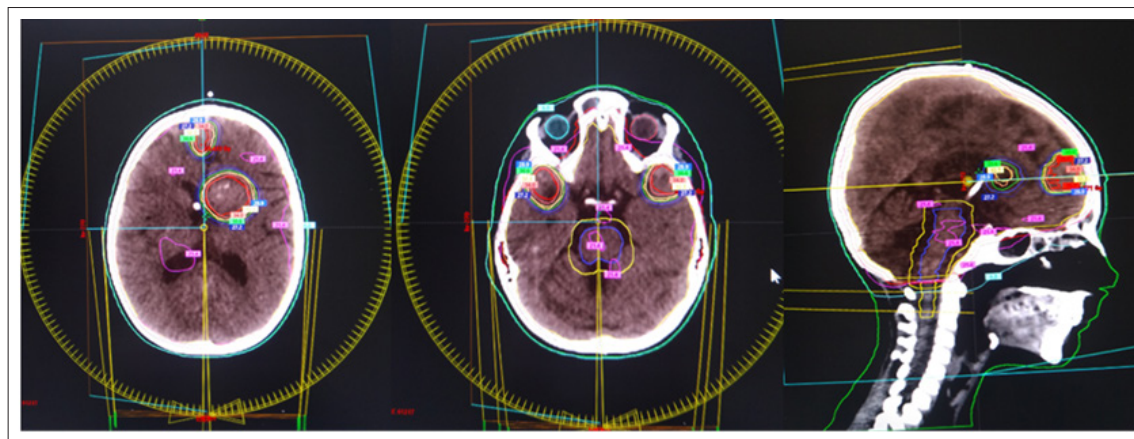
The Intensity Modulated Re-Irradiation in the whole Brain area with a Daily Dose (DD) 1.5 Gy to a total dose (TD) 22.5 Gy with a Simultaneous Boost in the Areas of the MRI-Visible Leptomeningeal Nodular Lesions / Caudate Nucleus, Anterior Frontal and Bilateral Temporal Retrobulbar/ with a DD 2.26 Gy to a TD of 34 Gy/ EQD2 36,21Gy.
